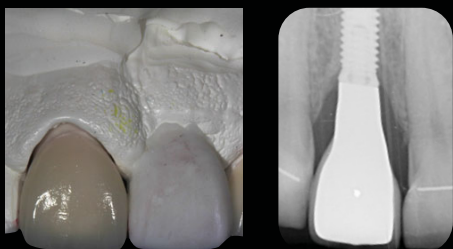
Definitive crown and post placement x-ray
